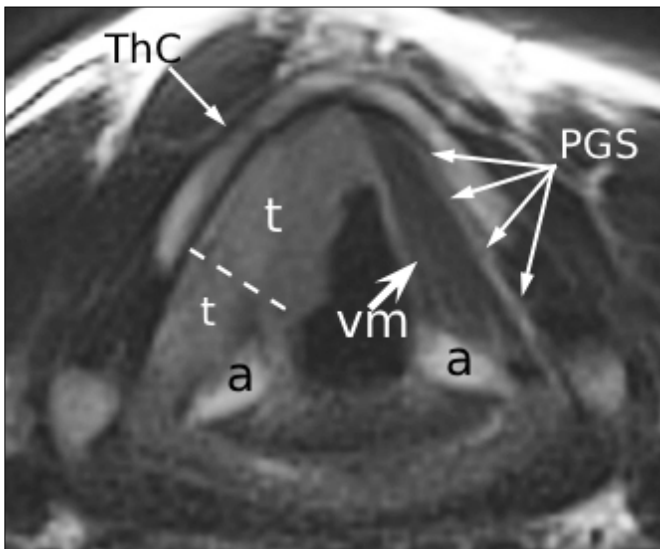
Axial T2-weighted MRI of a right glottic tumour (t) with endoscopically fixed vocal cord and arytenoid, involving both the anterior and posterior iPGS through the interrupted white line tangential to the arytenoid (a) vocal process and perpendicular to the thyroid cartilage lamina (ThC). On the left healthy side, the normal fat tissue filling the iPGS lateral to the thyroarytenoid vocal muscle (vm) is shown for clarity.
